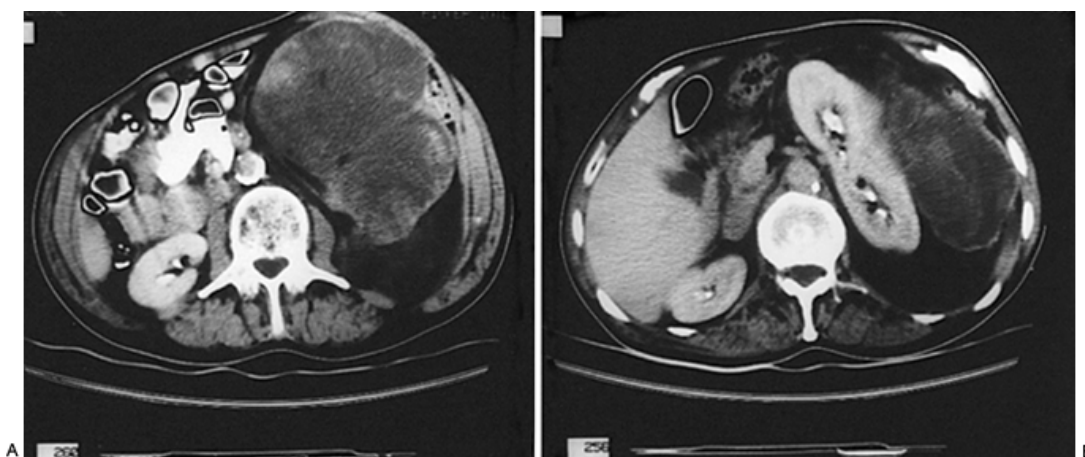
A: Computed tomography scan through upper abdomen demonstrates the presence of a huge, left-sided retroperitoneal liposarcoma. The mass is composed of tissues of varying densities, including soft tissue and fat. In contrast to benign lipomas, retroperitoneal sarcomas frequently demonstrate only minimal amounts of fat. B: Scan from same patient several cuts lower demonstrates relationship of mass to medially deviated left kidney that was resected en bloc with the tumor.
